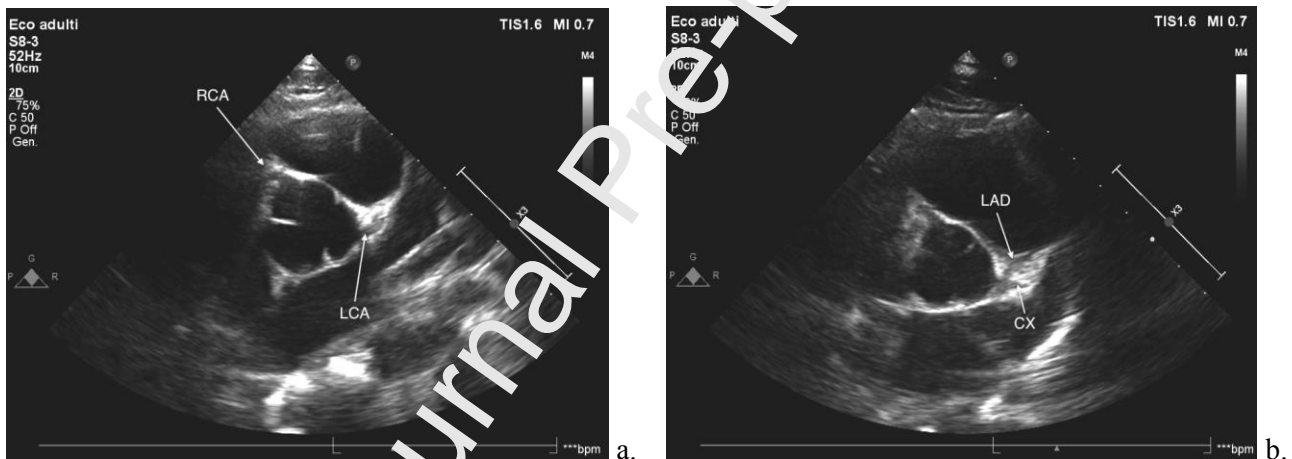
TTE of normal coronary arteries (parasternal short axis projection). Coronary ostia (a) and LCA bifurcation (b). CX: circumflex coronary artery, LAD: left anterior descending artery, LCA: left coronary artery, RCA: right coronary artery.
